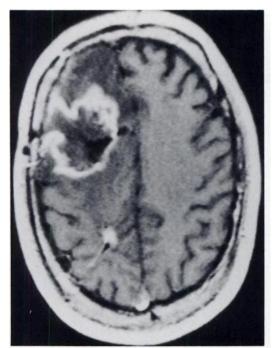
MRI, Patient 2. A T1-weighted axial plane image following the administration of gadolinium demonstrates an irregular enhancing lesion in the right fronto-parietal region. Central necrosis and possibly internal debris were also identified.
